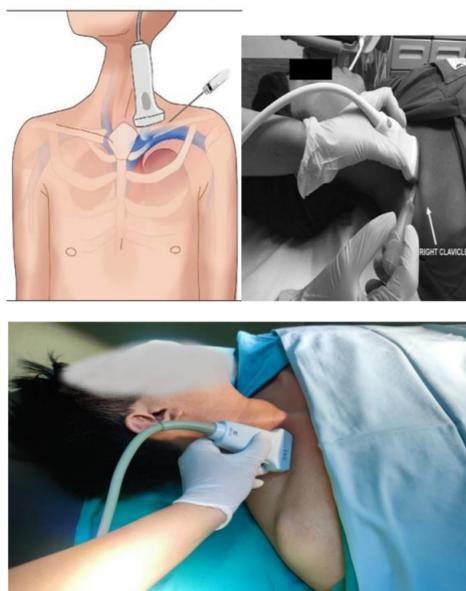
Ultrasound probe positioning and needle path in the supraclavicular approach.
